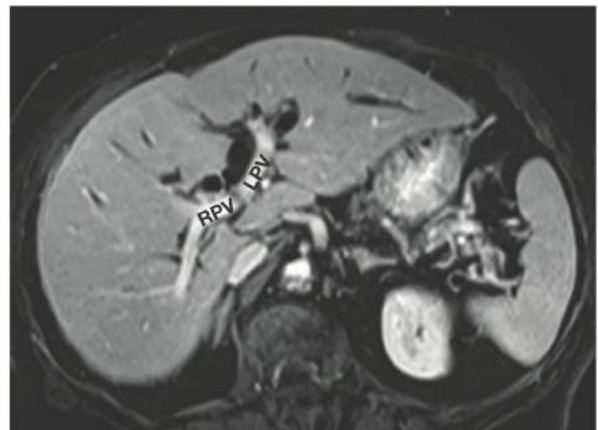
• MRI during the portal venous phase showing the right portal vein (RPV) and left portal vein (LPV). The dilated left hepatic duct (LHD) lies anterior and superior to the LPV.
